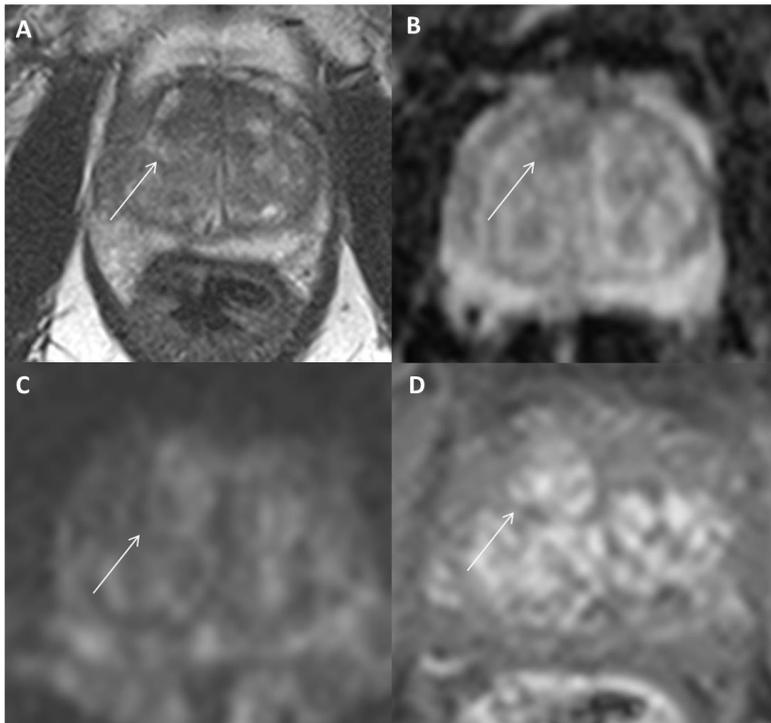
Sixty-eight-year-old man presenting with increasing prostate specific antigen (from 6 to 12 ng/ml) and three sets of negative biopsies. The arrows indicate an area in the right para-sagittal anterior transition zone characterised by low signal on T2-weighted imaging (A) and moderate enhancement on dynamic contrast enhanced imaging (B). The lesion is not conspicuously bright on long b value sequences on diffusion-weighted imaging (C), but there is some associated restricted diffusion on the apparent diffusion coefficient map (D). The area was scored as 3/5 on a Likert scale. The subsequent targeted biopsy did not show any cancer
